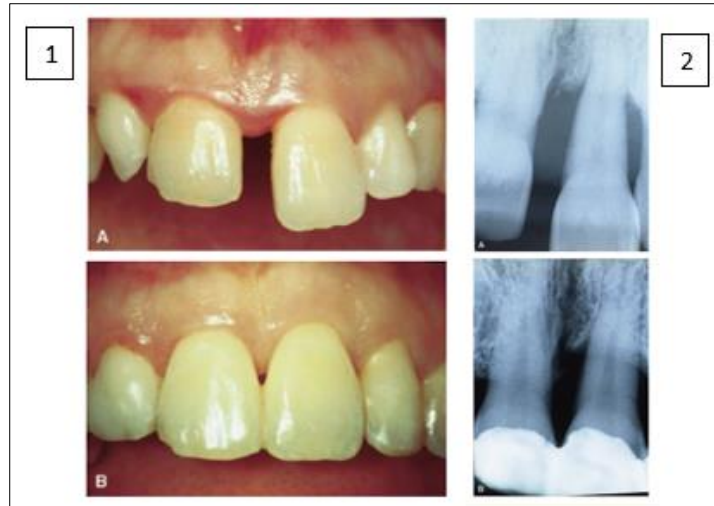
1) Clinical documentation. A) Before therapy. B) After orthodontic therapy. 2) Radiographic documentation of patient Y. A) Bone defect at baseline examination. B) Bone modifications following periodontal surgery and intrusive orthodontic therapy ⁽⁴²⁾.
